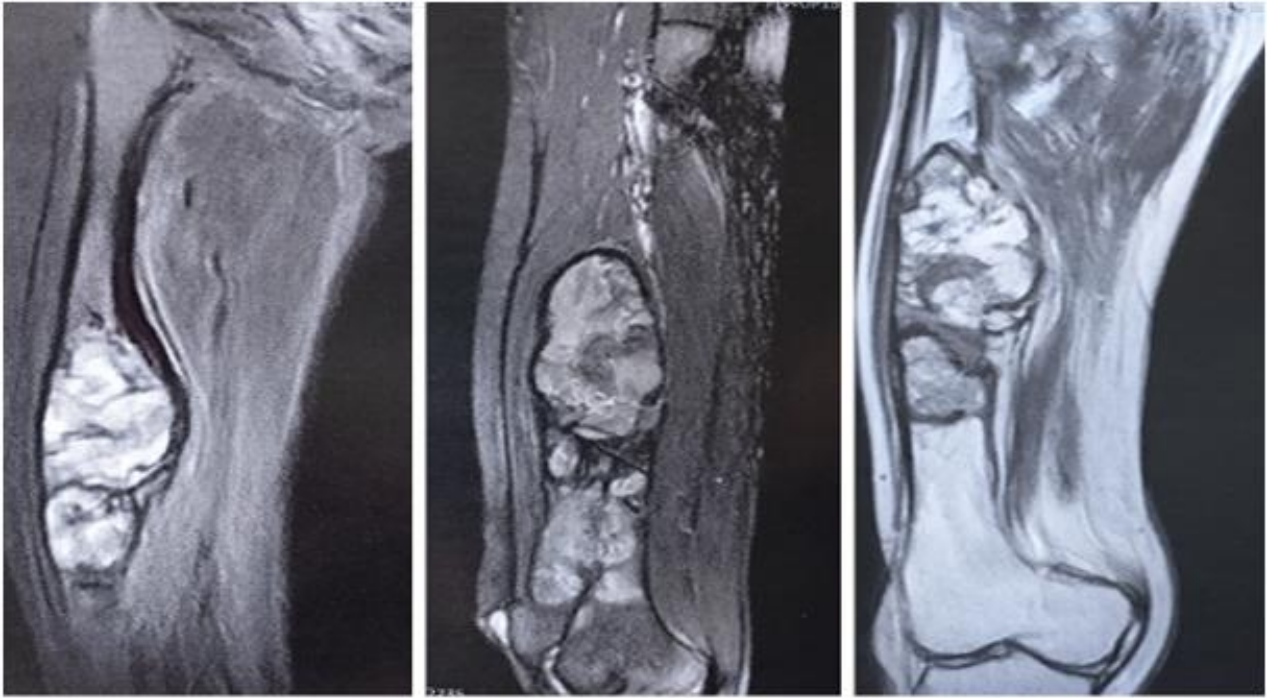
Figure shows sagittal, coronal, and axial MRI of the right femoral shaft, revealing a multiloculated, expansile lytic lesion with fluid-fluid levels, suggestive of an aneurysmal bone cyst (ABC) but not excluding telangiectatic osteosarcoma (TOS)
